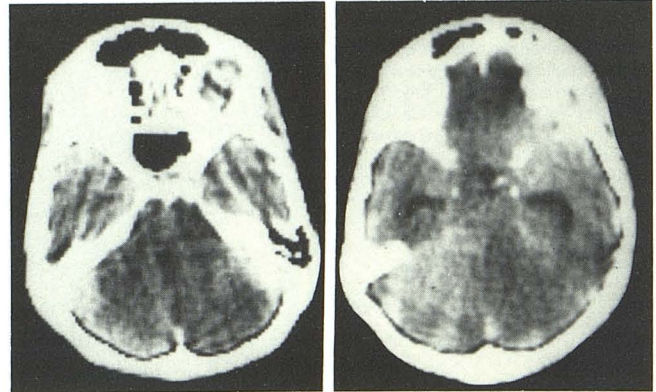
Case 4. Contrast CT. Low density in right side of brainstem and superior vermis, and partial obliteration of left ambient cistern.
